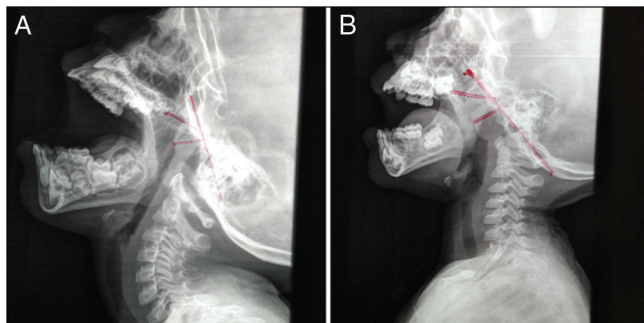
X-ray postnasal space of mild (A) and severe (B) adenoid enlargement
